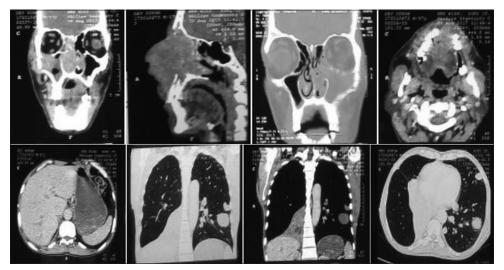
Contrast-enhanced computed tomography of head and neck, thorax, and upper abdomen
